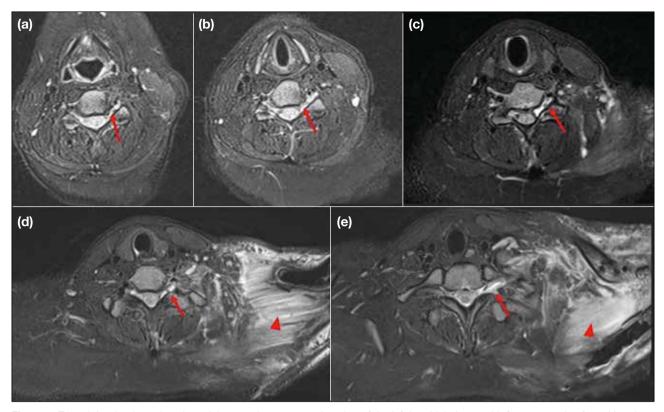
T2-weighted turbo spin echo axial magnetic resonance imaging of the left brachial plexus with fat suppression (repetition time: 5480 ms, echo time: 85 ms): The left C5 nerve root (a) is continuous but thickened (red arrow). There is T2-weighted hyperintense cystic signal along C6 to T1 nerve roots at foraminal level (b-e) [red arrows], suggestive of pseudomeningocele indicating preganglionic injury. The C6 nerve root (b) was seen to be continuous but thickened with T2-weighted hyperintense signals, suggestive of traction injury (red arrow). Indistinct C7 (c) and C8 (d) nerve roots with T2-weighted hyperintense signals were suggestive of high-grade injury (red arrows). Indistinct T1 nerve root (e) replaced by cystic signal was suggestive of neurotmesis (red arrow). The T2-weighted hyperintense signals at the left supraspinatus muscle (red arrowheads in [d] and [e]) could be due to trauma or acute denervation.
